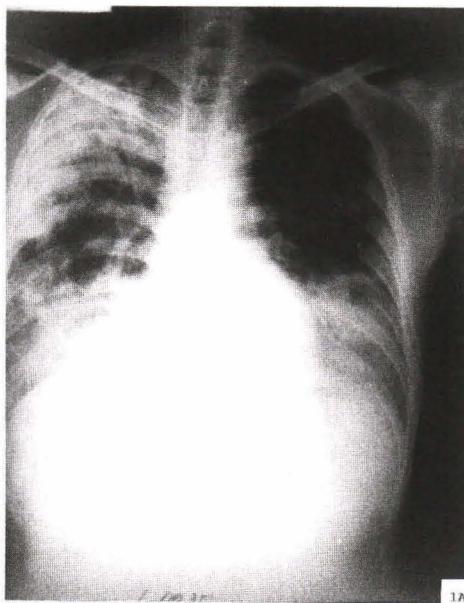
Chest radiograph of a patient with pulmonary sparganosis demonstrating multiple patchy infiltrations which were initially greater in the right lung.
